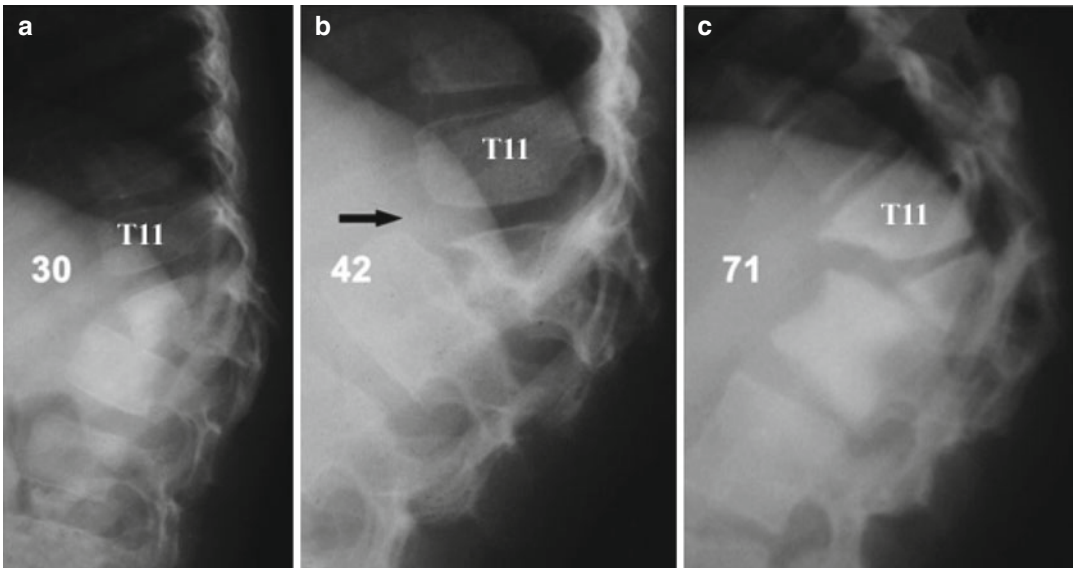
Lateral radiographs of the thoraco-lumbar spine demonstrating kyphosis progression in a 8 year old child. (a) The deformity measures only 30 degrees at the completion of chemotherapy. Over a period of 5 year follow-up, the deformity gradually worsens from 42° at 5
